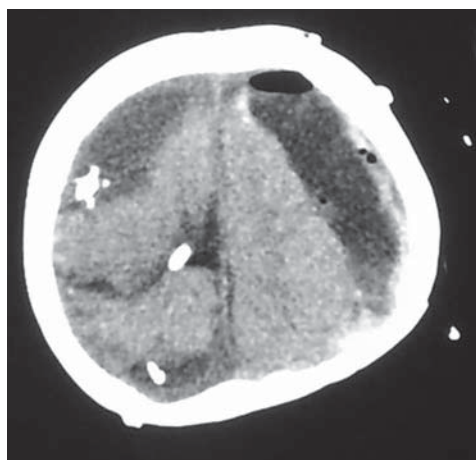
Post OP CT Scan which revealed some expansion of the compressed brain
